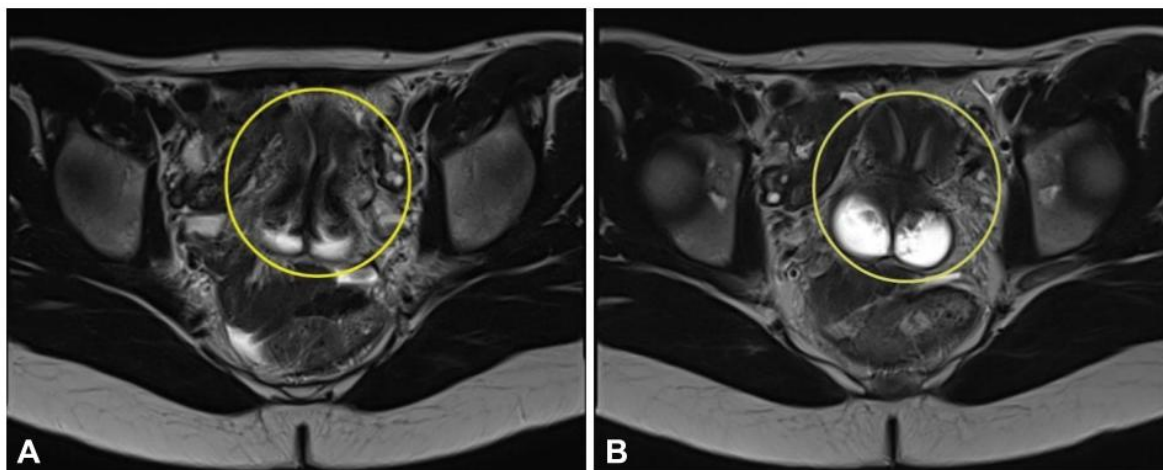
Axial pelvic magnetic resonance imaging: (A) longitudinal section demonstrates an elongated endometrial cavity divided by a T2 hypointense septum, consistent with a fibromuscular tissue, resulting in complete partitioning of the uterine cavity; (B) longitudinal section demonstrates cervical duplication, with two distinctly separate uterine cervixes, each maintaining anatomical continuity with its respective endocervical canal. This finding is compatible with a Müllerian duct anomaly.
